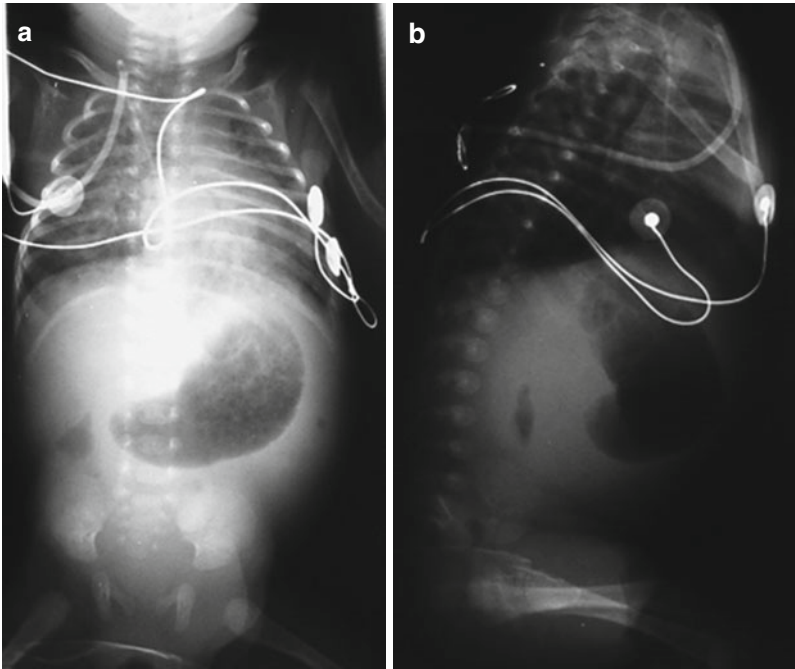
Abdominal plain film in newborn with HPS. (a) Frontal and (b) lateral views show a large distended stomach, with an abnormal distance between the stomach and the duodenal cap, both distended by air
